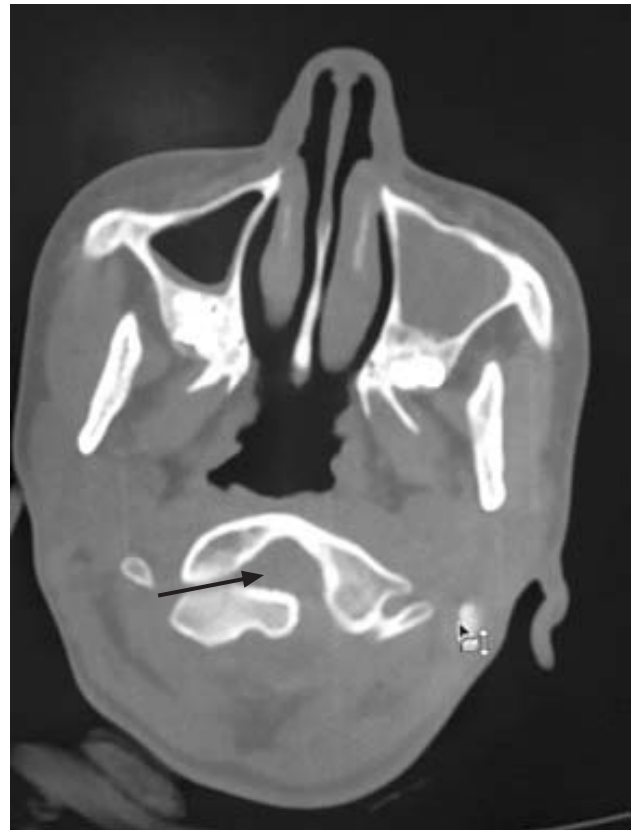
CT axial section Bone window Increased atlantodens distance.
